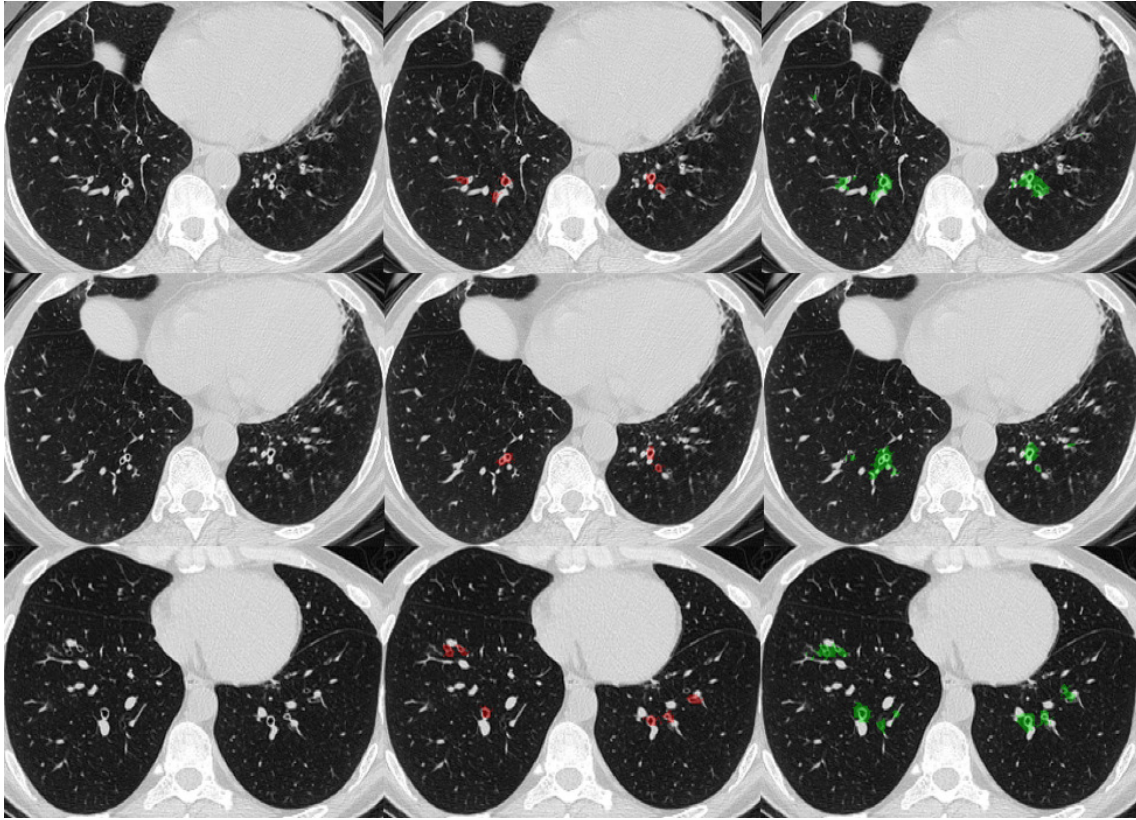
Examples of bronchiectasis segmentation on three adjacent slices. *Left* - axial CT slice, *middle* - segmentation by a radiologist, *right* - predicted segmentation by RFC-DenseNet.
